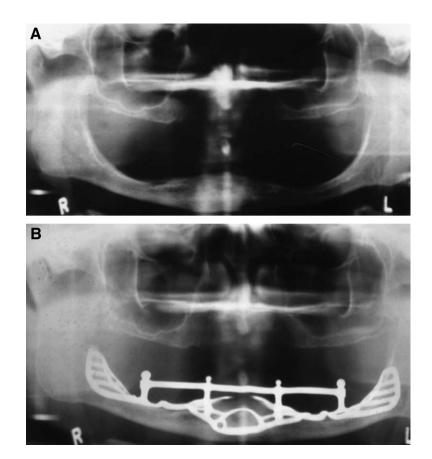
Panoramic radiograph of a study participant. A, Prior to implant placement. B, After implant placement.
